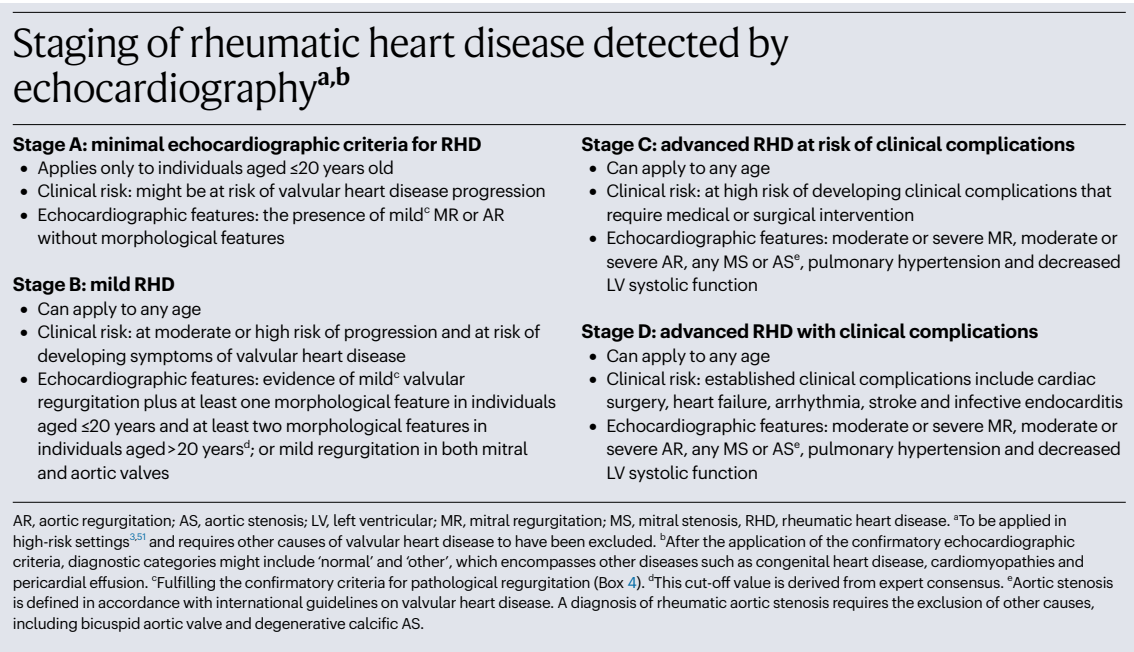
Staging of rheumatic heart disease detected by echocardiography
